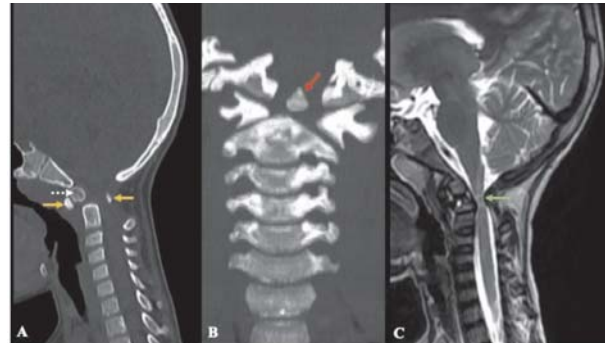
Sagittal CT spine (A and B) and Sagittal MR Spine (T2W sequence) images show Os odontoideum (dashed arrow) with anterolisthesis of the whole of C1 and Os odontoideum over C2 vertebral body, anterior displacement of anterior and posterior arches of the atlas (C1) (yellow arrow) and rotatory atlantoaxial joint subluxation (red arrow in B). The resultant significant narrowing is seen at the C1-C2 level with compression and kinking of cervicomedullary junction with altered signal intensity (green arrow in C).
